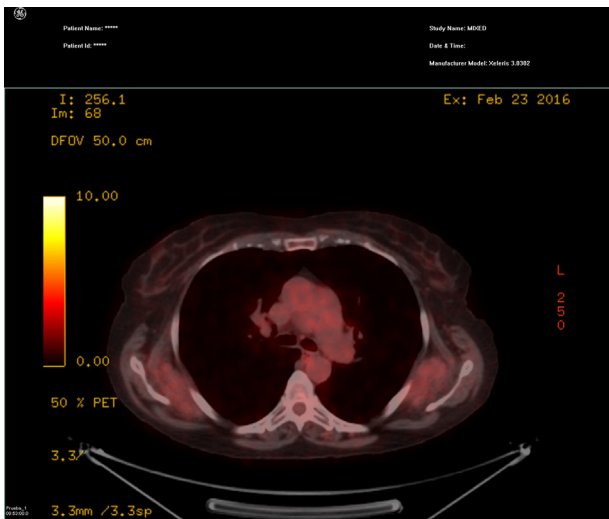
A moderate degree of FGD uptake in the bilateral masses located in the subscapular region (SUV max.lbm of 2.1 in the right side and 2.2 in the left) diagnosed in a previous CT as elastofibroma dorsi.
